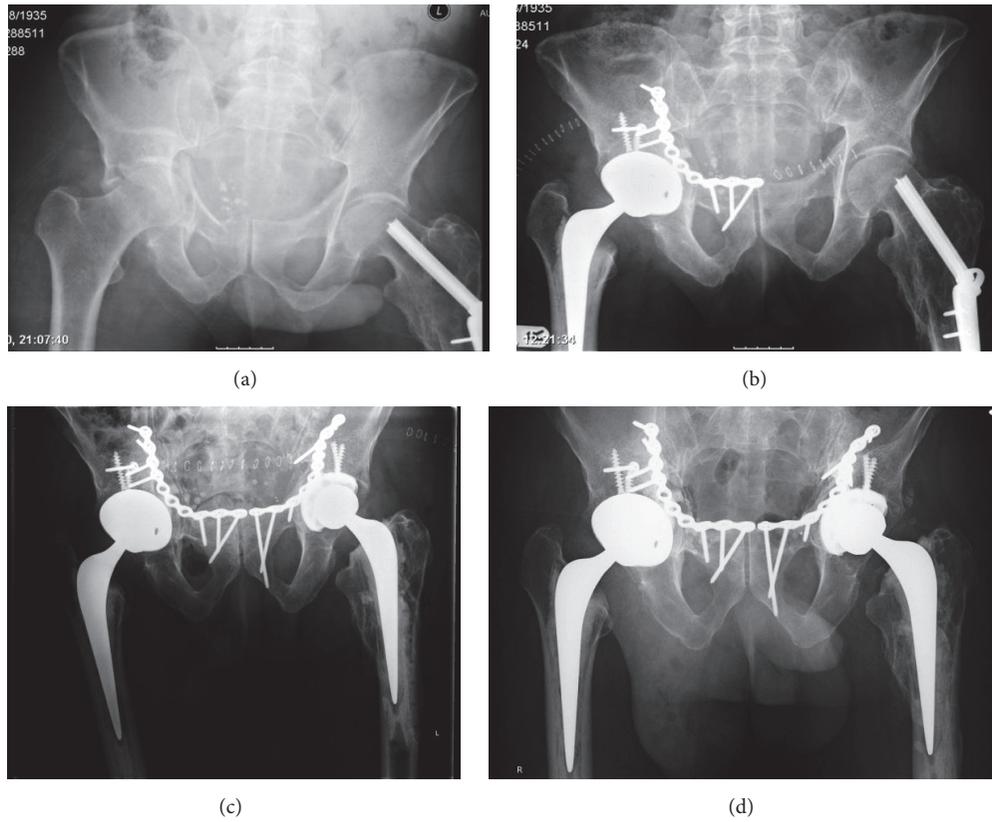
Images of patients 4 and 25, who sustained bilateral fractures at different time points. (a) Initial fracture in January 2010. (b) Postoperative view in January 2010. (c) Postoperative X-ray after second surgery in January 2012. (d) Most recent X-ray in June 2015.
